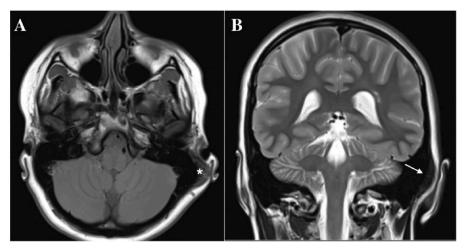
Preoperative MRI. (A) Axial T1W1 with isointense signal lesion (asterisk). (B) Coronal T2W1 with hypointense signal lesion (arrow). MRI indicates magnetic resonance imaging.
